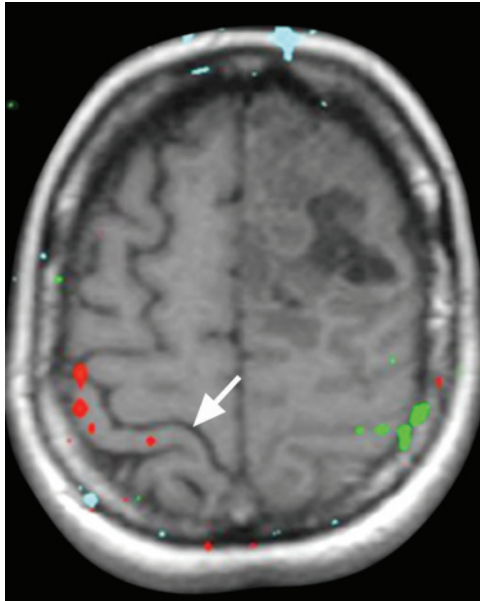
Functional MRI. BOLD image shows activated red areas (on the right side) and green areas (on the left side) in the postcentral gyrus (motor cortex) from hand fingers movement. Arrow indicates right central sulcus. Patient has a tumor in the left frontal lobe
